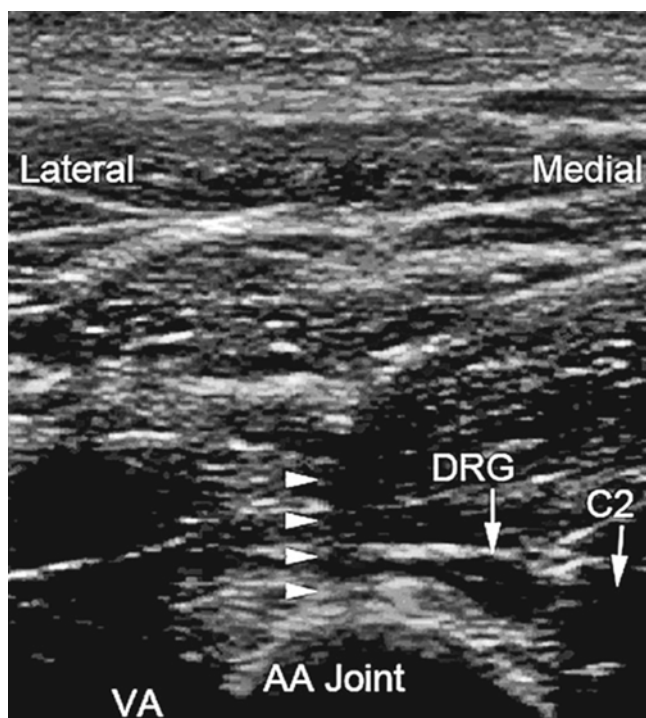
Atlanto-axial joint (AAJ) injection. Short axis sonogram showing the needle targeting the AAJ (*arrowheads*). C2 C2 nerve root, DRG dorsal root ganglion, VA vertebral artery (Reproduced with permission from Ohio Pain and Headache Institute)
